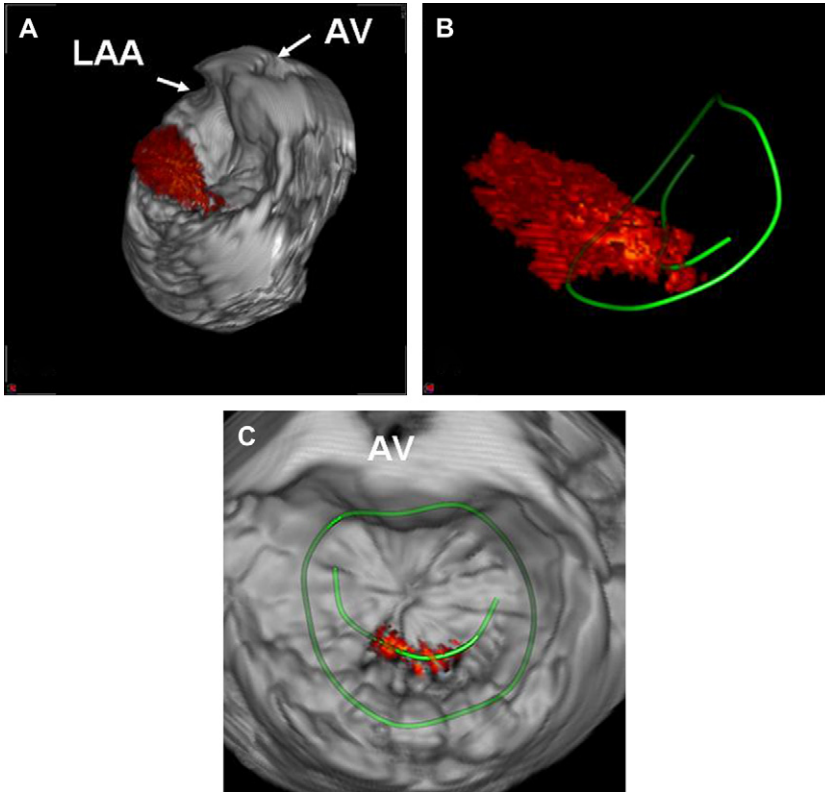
(A) Transesophageal 3D reconstruction of mitral valve regurgitation. The relationship between regurgitant jet, mitral valve annulus, and coaptation line are visualized (B). The jet at the level of the mitral valve is shown (C), allowing easy assessment of its exact spatial location (4D MV-Assessment CAP, TomTec Imaging Systems, Unterschleissheim, Germany). *Abbreviations:* AoV, aortic valve; LAA, left atrial appendage.
